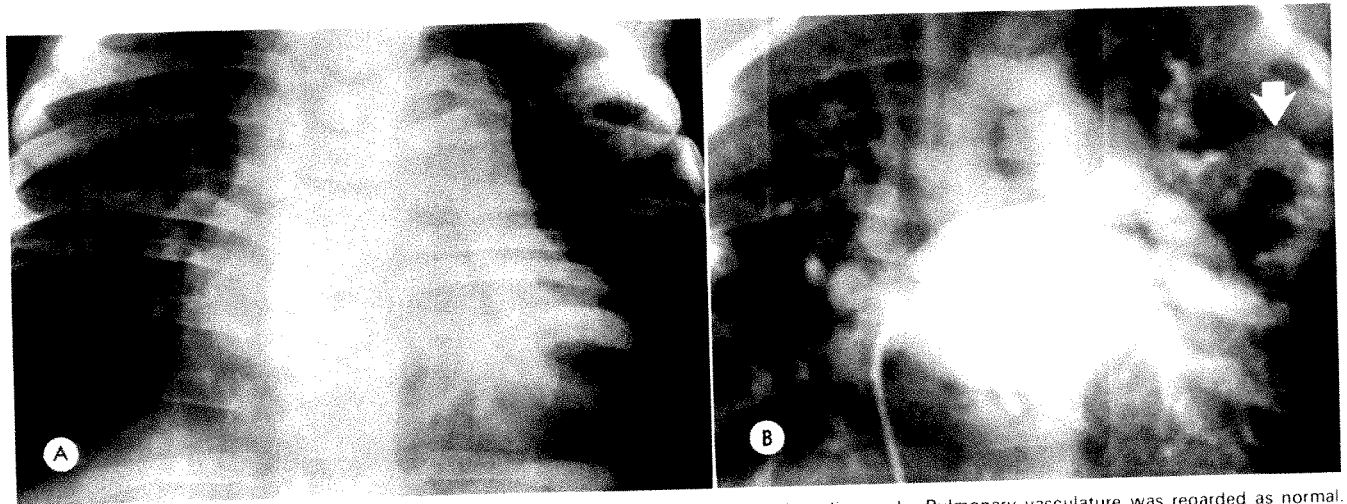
Case 3. *A*, Chest radiograph showing multiple rib anomalies and generalized cardiomegaly. Pulmonary vasculature was regarded as normal. *B*, Levophase of right ventricular angiogram demonstrating large varicose pulmonary vein in left midlung field (arrow). Major pulmonary veins all enter left atrium. They are dilated because of large left-to-right shunt.
